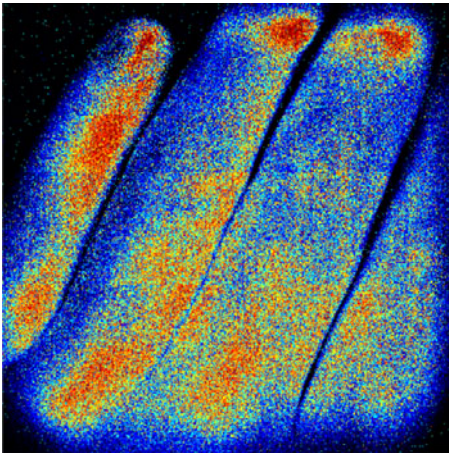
Laser Doppler Image
